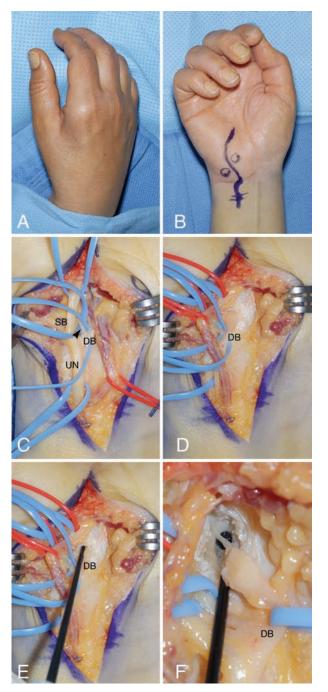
Deep ulnar nerve paralysis in the distal ulnar tunnel. A, this 52-year-old woman presented with progressive atrophy of the first dorsal web space and hand weakness due to ulnar innervated intrinsic paralysis over an 18-month period of time. She had preserved abductor digiti minimi function. Sensation in the hand was normal. Electrodiagnostic studies confirmed a lesion of the ulnar nerve isolated to the deep branch of the ulnar nerve. MRI scans did not reveal a mass (joint-related ganglion may produce this presentation). Entrapment of the deep branch (distal to the abductor digiti minimi branch) by the hypothenar fibrotic arch is a relatively rare, but well known, entrapment. One should always consider
